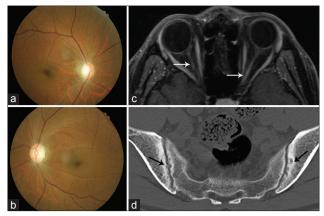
The image evidences of optic neuritis in our clinic (20 days after onset). The appearance of optic discs were pale with blurred border in both right (a) and left (b) eyes; (c) Orbital magnetic resonance imaging showed gadolinium enhancement in bilateral optic nerves (white arrow). (d) Computed tomography revealed bilateral sacroiliitis (black arrow).
